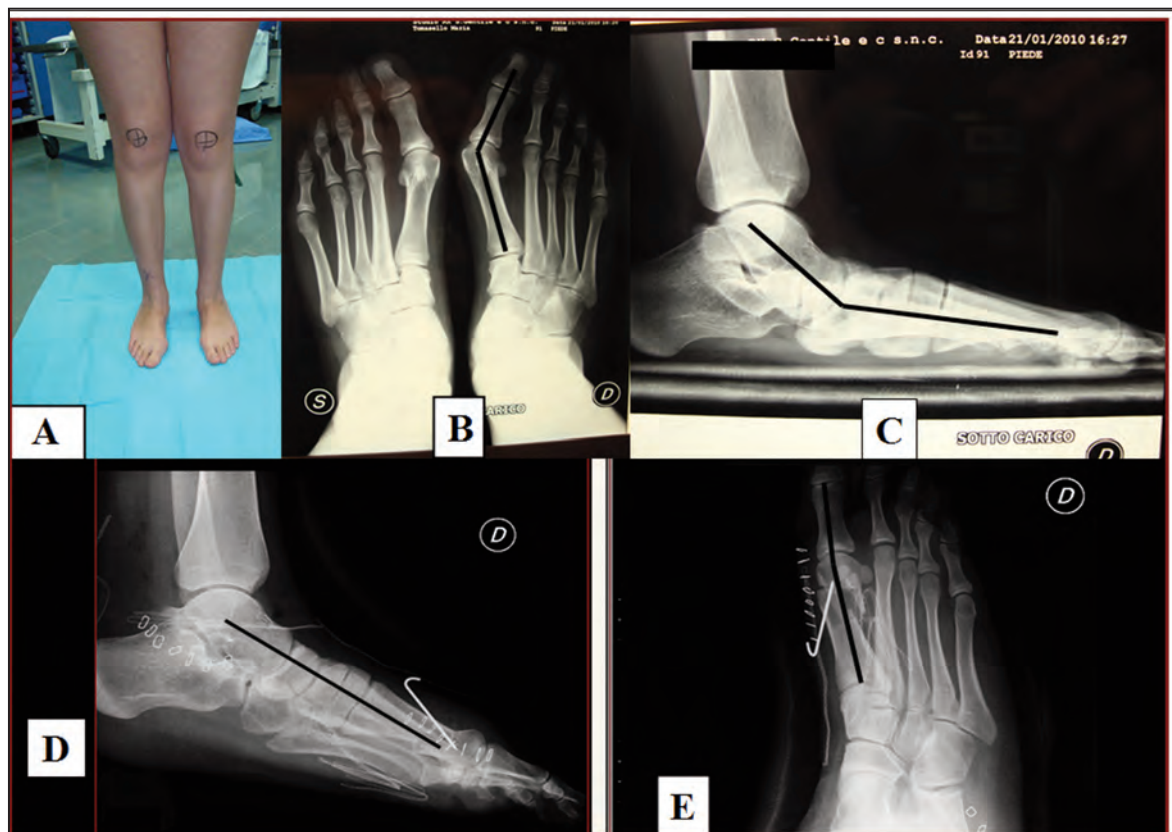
Case 5: 18-year-old female student with Hallux Valgus in bilateral flatness (A-B-C). The X-ray control of the right foot post-intervention "Grice arthrodesis + tenotomy with Z-lengthening of the Achilles tendon + First Metatarsal osteotomy closing the metatarsal fan" documents the reconstitution of the plantar vault and optimal closure of the metatarsal fan (D-E).
